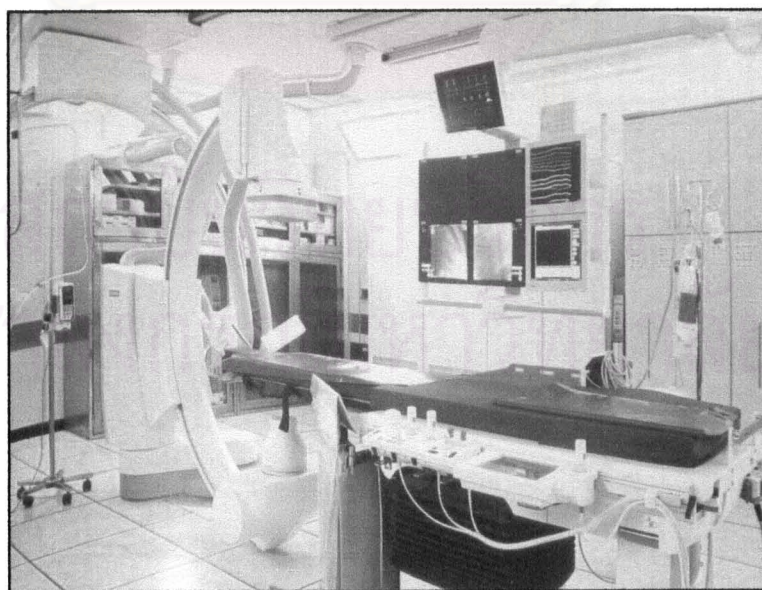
Radiographic-fluoroscopic machines for DCA, PTCA/stent procedures (Siemens, Axiom-Artis)
